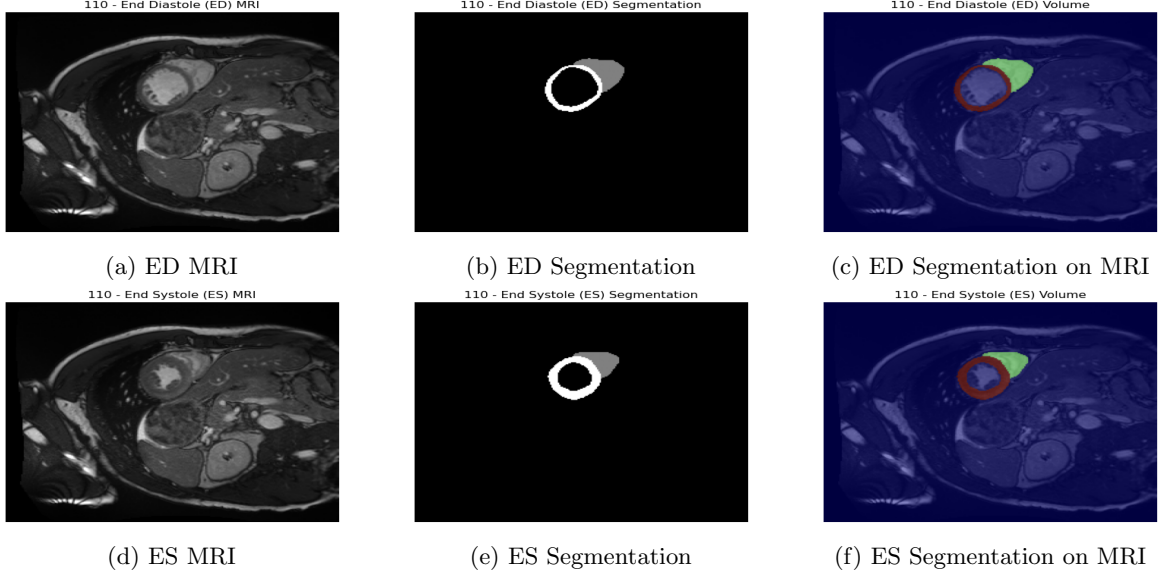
MRI segmentation provided for a patient in the test dataset
